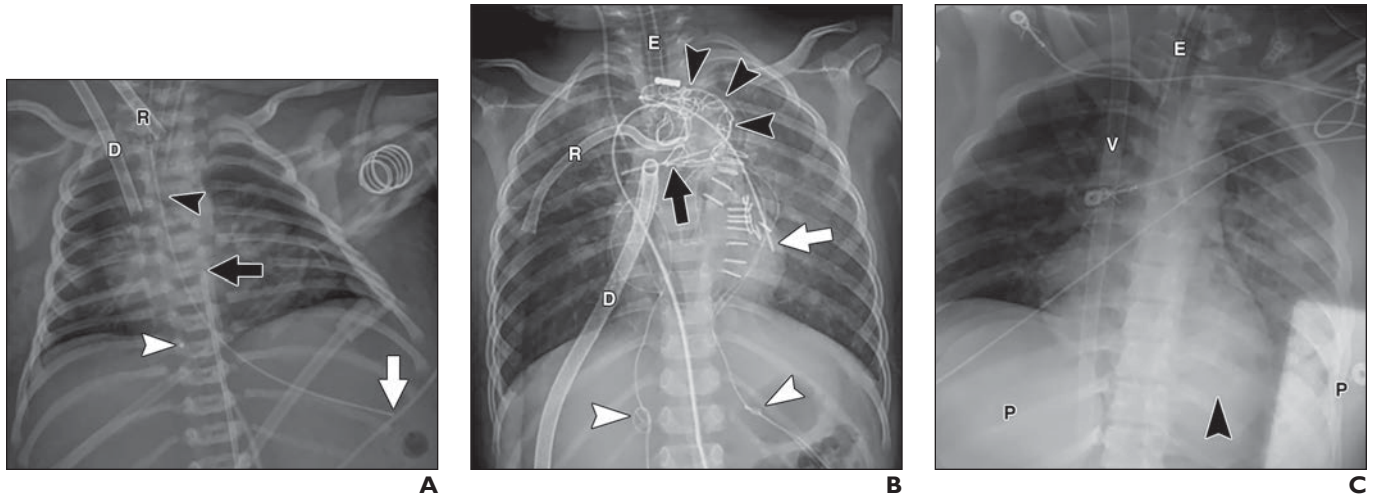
Radiographic appearance of different modes of extracorporeal membrane oxygenation (ECMO).
